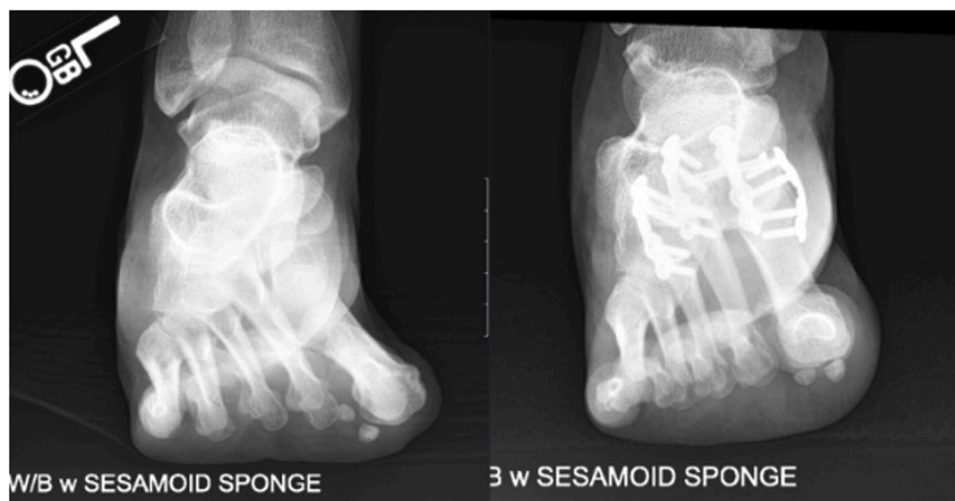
Pre-operative (left) and post-operative (right) sesamoid axial plain films depicting a reduction in tibial sesamoid position.
